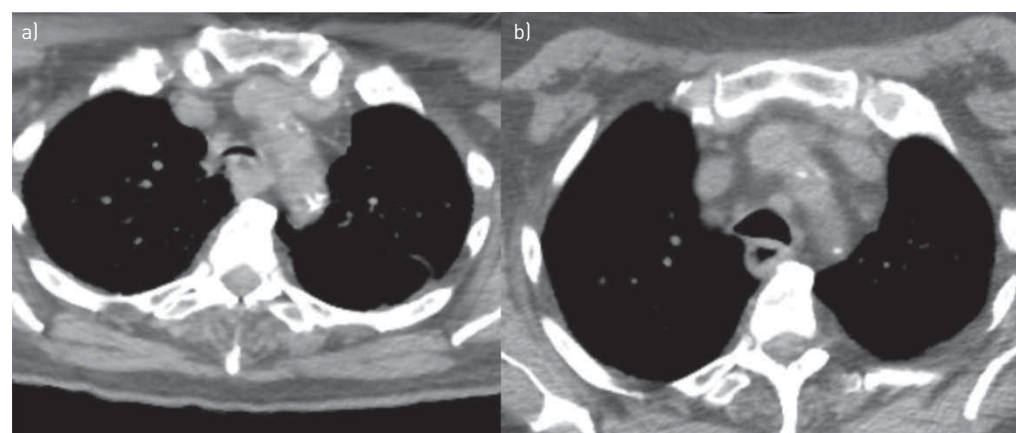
a) Admission computed tomography (CT) scan showing near complete collapse of trachea in a patient that was subsequently diagnosed with relapsing polychondritis. b) Repeat CT after intravenous corticosteroids with inspiratory and expiratory films showing significant improvement of tracheal narrowing (expiratory phase CT).
